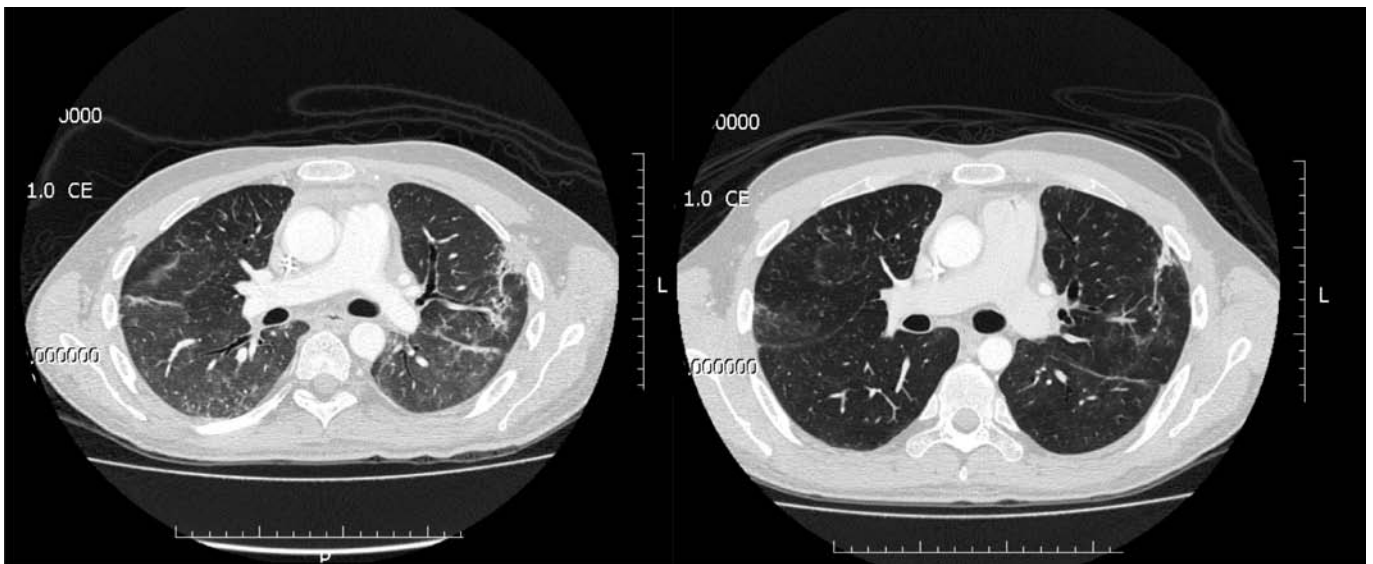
Thoracic computed tomography at hospital discharge (left) and 1 month later at outpatient monitoring (right). Therapeutic monitoring indicating significant reduction compared to previous exams in the extent of pulmonary opacities, disappearance of pneumomediastinum and pleural effusion at hospital discharge. Computed tomography exhibiting considerable radiological improvement at outpatient monitoring.
